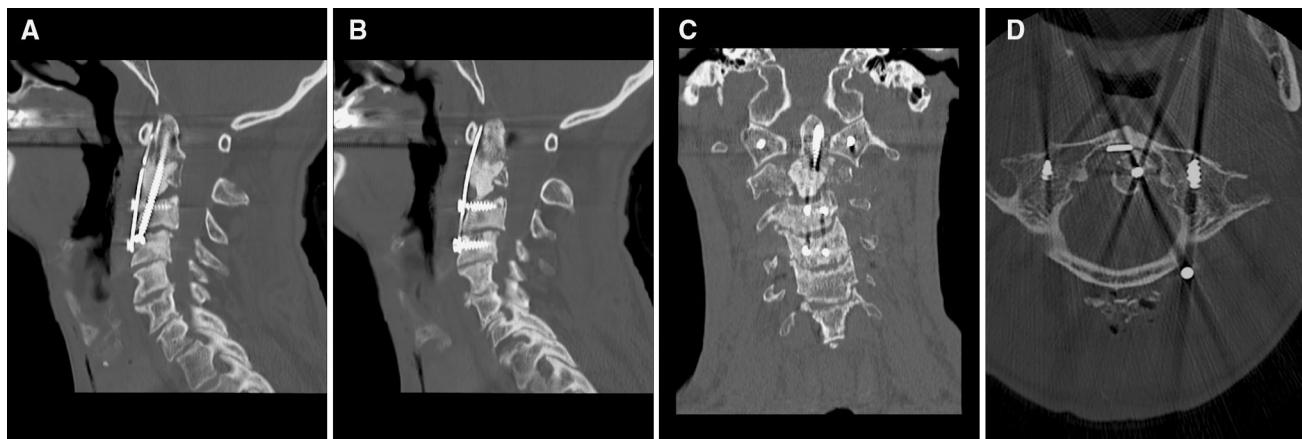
Postoperative CT scan showing the final construct with reduction of the C1–C2 dislocation on the sagittal (a, b), coronal (c) and axial (d) cuts
